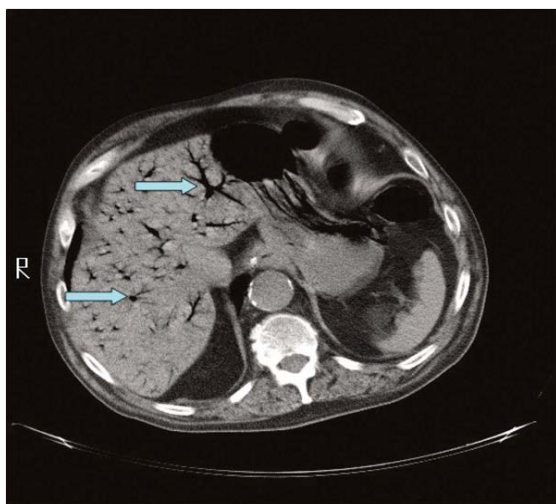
Computed tomography of the abdomen, the blue colored arrows identify and shows the hepatic portal venous gas.
